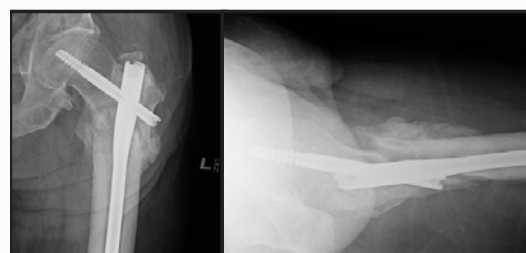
The patient radiographs 8 months postop.
